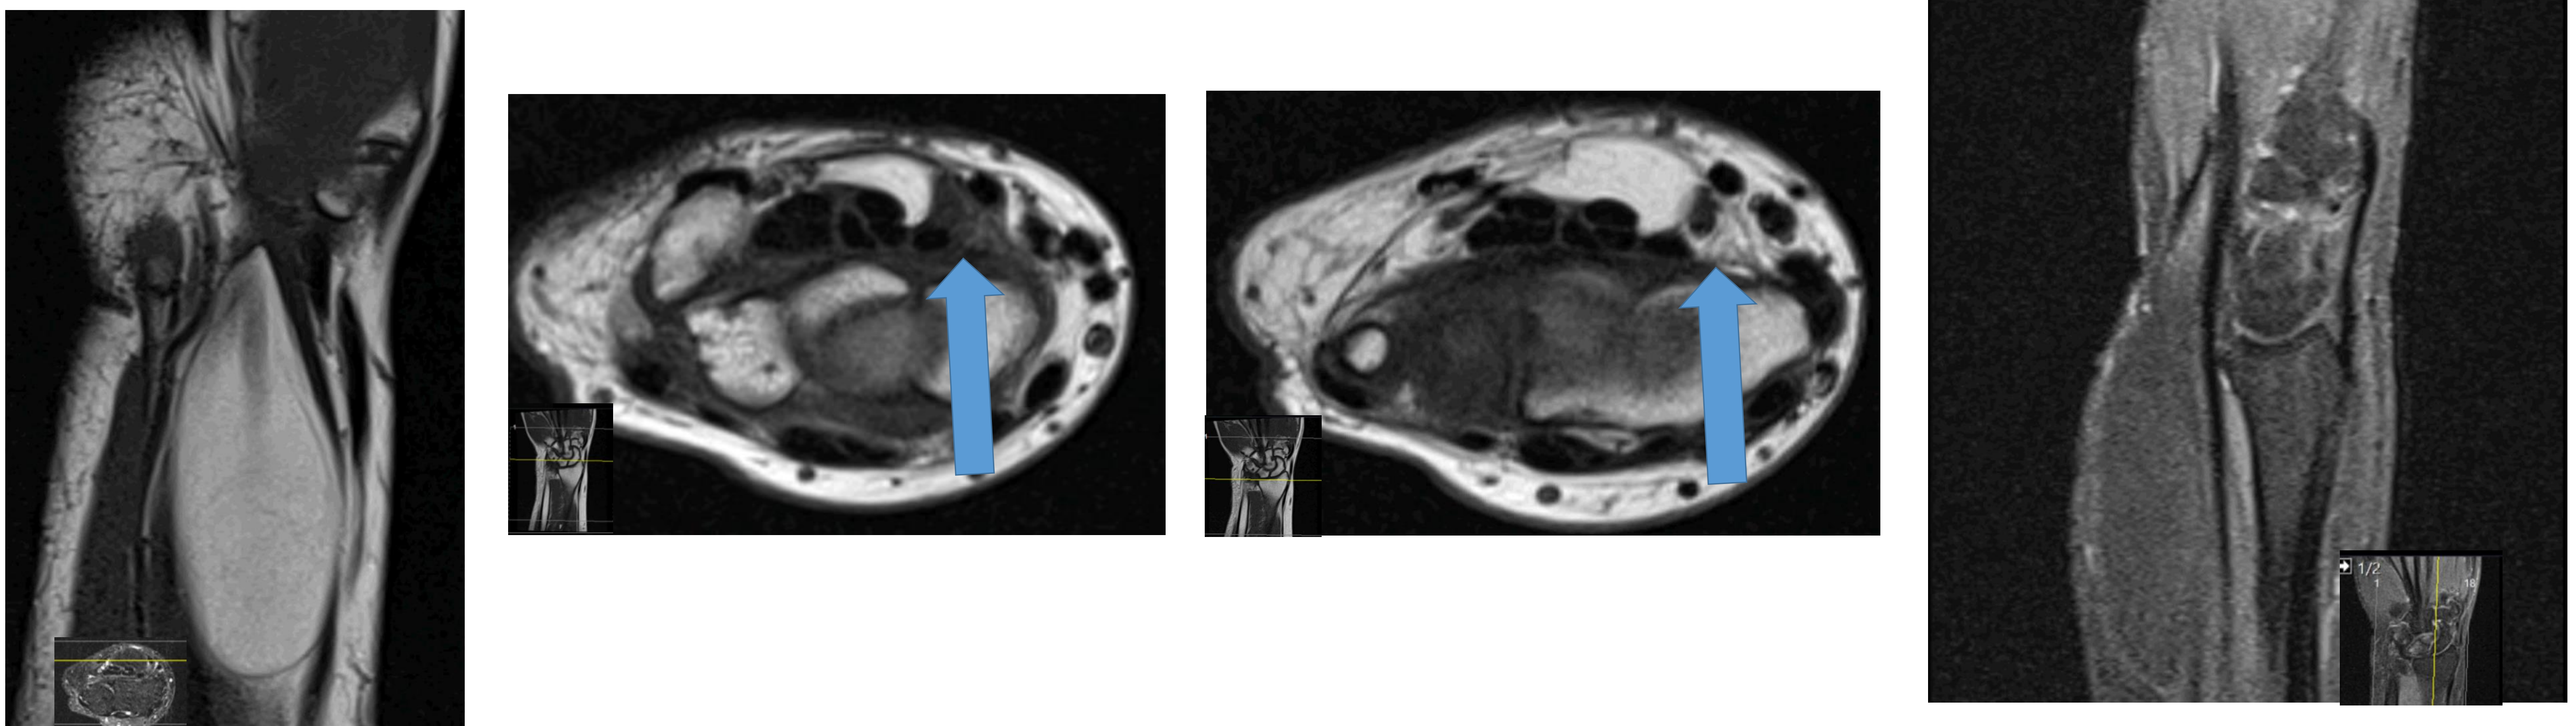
(MRI): Coronal, sagittal and axial views of the wrist. Arrow – median nerve.
